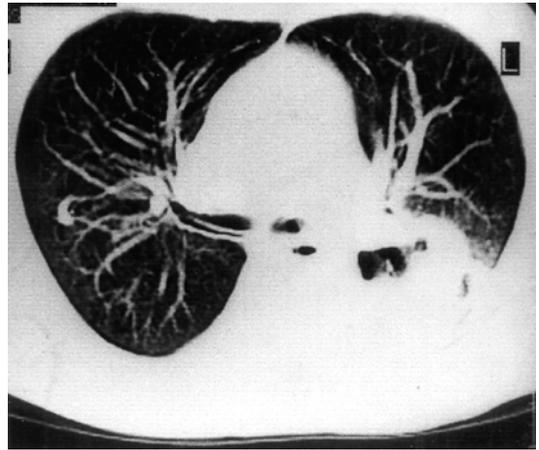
The chest CT scan showed a huge mass in the posterior segment of left upper lobe and the superior segment of left lobe. It disclosed the multiple cavitory or cystic lesions and air bronchograms.
